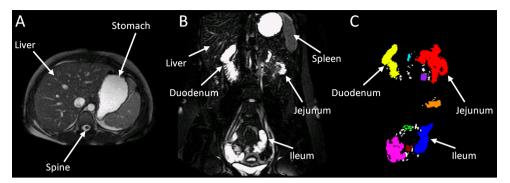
Examples of MRI images. Representative examples of MRI images acquired after a 240 mL dose of water in a healthy volunteer. (A) One axial image of the water drink inside the stomach. (B) One heavily T2 weighted coronal image of the abdomen. In this kind of MRI sequence the signal from tissue has mostly decayed and only bright signal from freely mobile water is seen. (C) The maximum intensity projection image of all the individual small bowel water pockets, color coded and extracted from the entire three-dimensional set of panel B and manually segmented.
